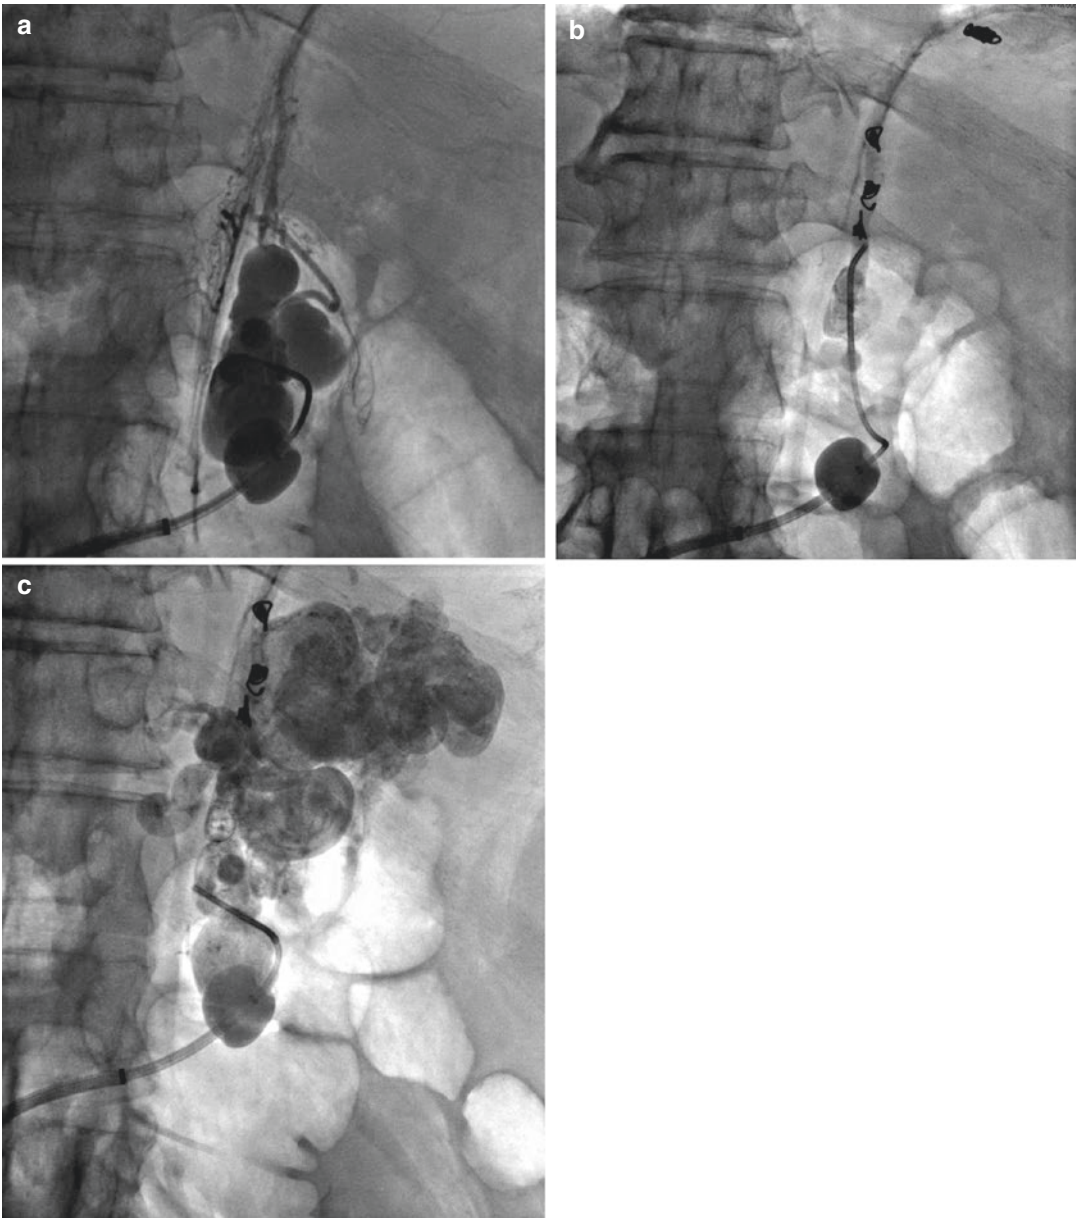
A 66 year old man with cryptogenic cirrhosis with known esophageal and gastric varices presented with hematemesis. A CT angiography demonstrated prominent true gastric varices, and he was referred for a BRTO procedure. (a) Angiographic view of a large gastric varix. (b) Coils were placed in the phrenic venous circulation to
